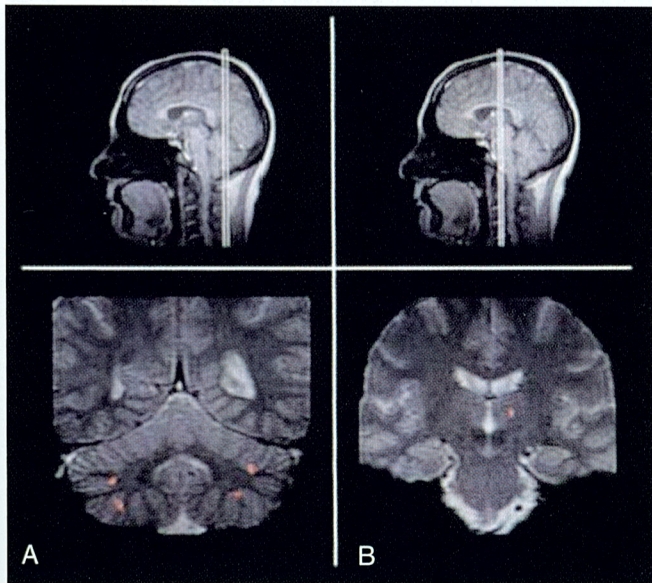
Functional brain changes in restless legs syndrome (RLS) (functional magnetic resonance imaging). Neural responses associated with sensory leg discomfort in a patient with idiopathic RLS. Activations are superimposed on two coronal T2-weighted magnetic resonance imaging sections, and the extents of activated areas were significant at $P < .05$ corrected for multiple comparisons. Activations were located in the cerebellum bilaterally (A) and in the contralateral thalamus (B). (From Bucher SF, Seelos KC, Oertel WH, Reiser M, Trenkwalder C. *Cerebral generators involved in the pathogenesis of the restless legs syndrome*. *Ann Neurol*. 1997;41:639-645. Copyright 1997, with permission from John Wiley and Sons.)
